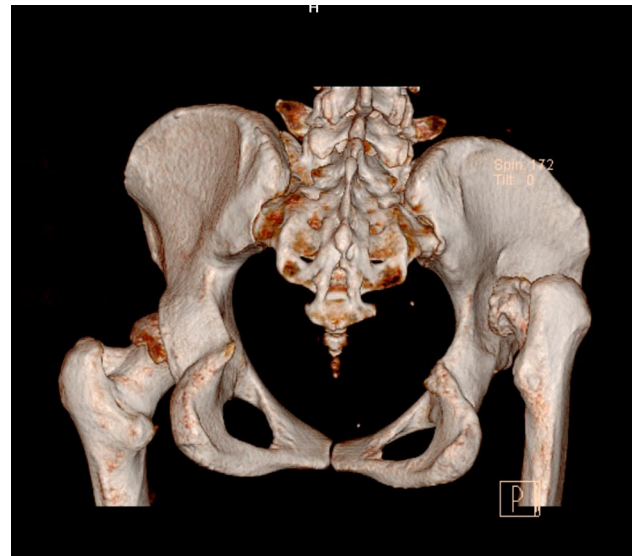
Anteroposterior pelvis 3D pelvis CT
